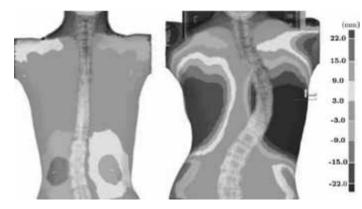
Back view of deviation colour map of patients with AIS. The spine shape was acquired from the corresponding radiograph and scaled to matched the ST
